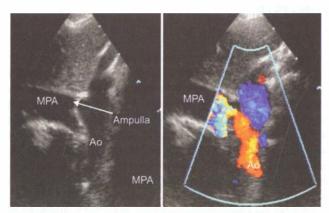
Echocardiography in patent ductus arterious (PDA). The frame on the left is a cross sectional two dimensional view of the PDA and the frame on the right is a color flow image. The red flow represents flow reversal in the descending thoracic aorta as a result of a left to right shunt across the PDA. Ao aorta; MPA main pulmonary artery
